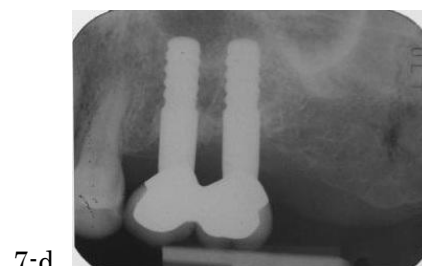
The temporal cement remnant causing decubital ulcer with perforation in the mucosa. Bone resorption was not observed in the dental radiograph. A perforation window remained for a period after the cement was removed with the probe.
